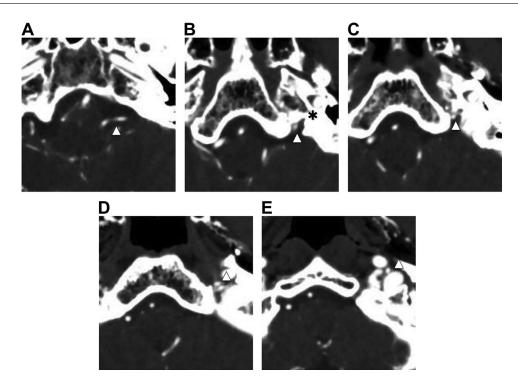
(A–E) CT angiography at the level of the jugular foramen (black asterisk) shows the anastomotic artery between the APA and PICA (white arrowhead) passing through the left jugular foramen pars vascularis.
